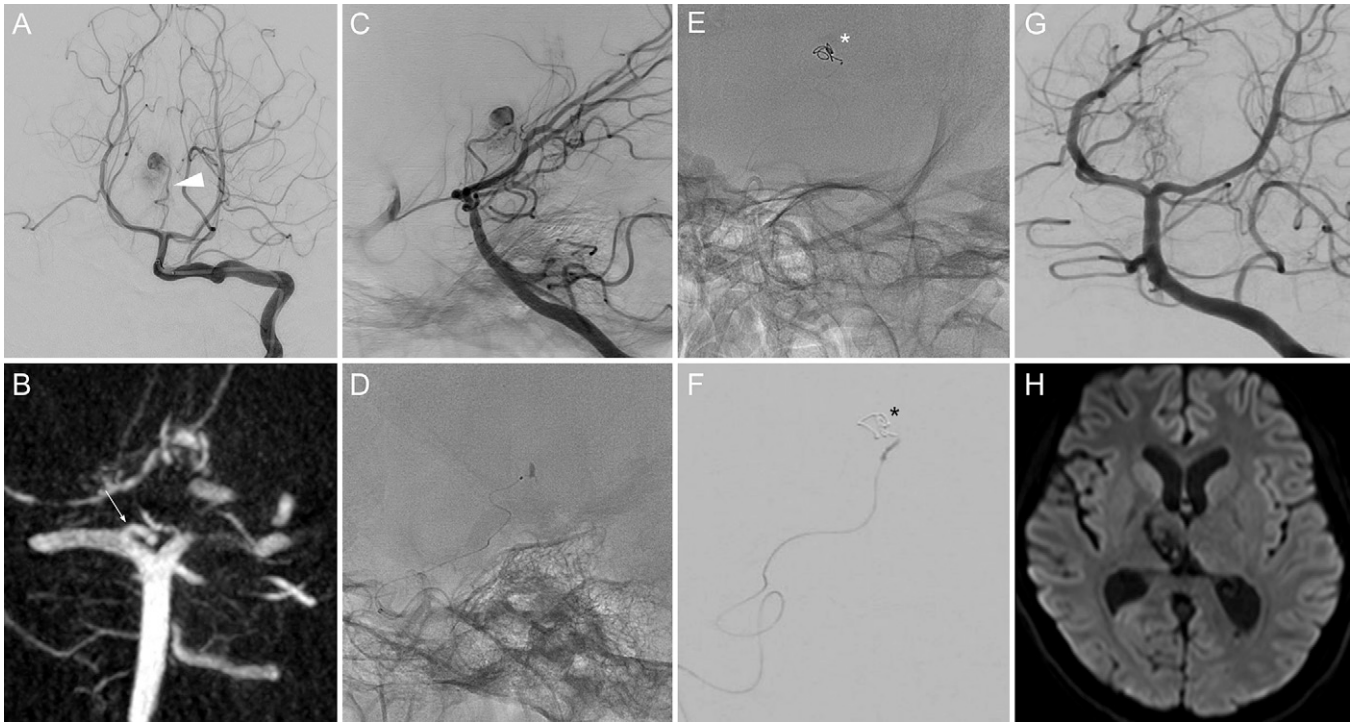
A: Anteroposterior left vertebral angiography (VAG) during endovascular treatment shows the right TPA feeder (*white arrowhead*). B: Coronal CTA shows the severe medial bend in the feeding artery (*white arrow*) that precluded navigation of the microcatheter via the BA. C: Lateral view of VAG with carotid compression shows the right PComA. D: Lateral view of VAG shows the microcatheter just proximal to the aneurysm. E and F: Right oblique views of VAG show aneurysm coiling (*white asterisk*) and glue application (*black asterisk*). G: Right oblique view of left VAG after embolization shows disappearance of the aneurysm and persistence of the nidus. H: Diffusion-weighted imaging after the procedure shows no cerebral infarction.
